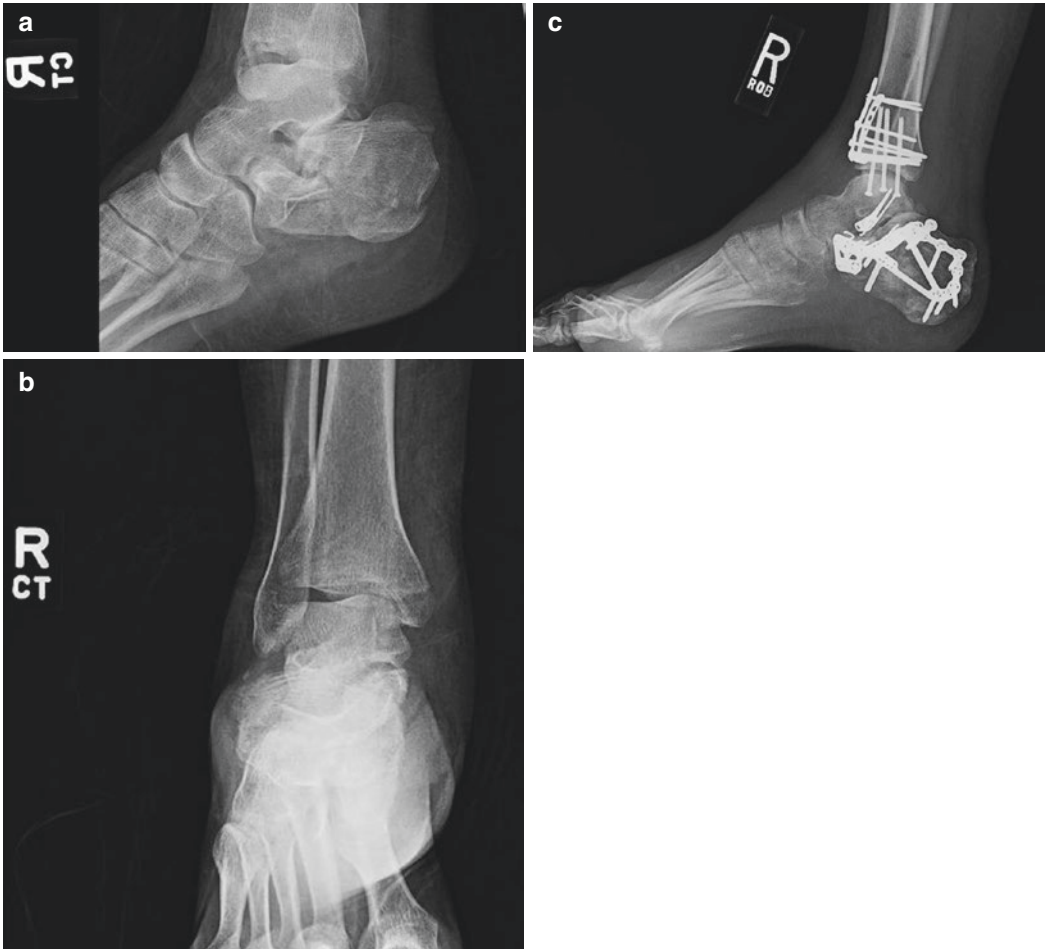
A lateral (a) and AP (b) X-ray of a patient who sustained a closed combined pilon, lateral process talus, and calcaneus fracture after a fall from height. A lateral (c) X-ray after definitive fixation of this combined injury
